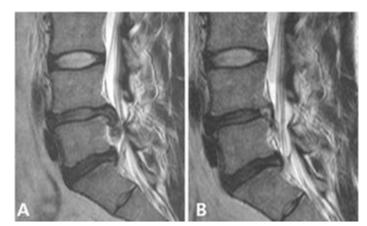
MRI lumbosacral spine, sagittal view, pre (A) and post-operative (B) images
